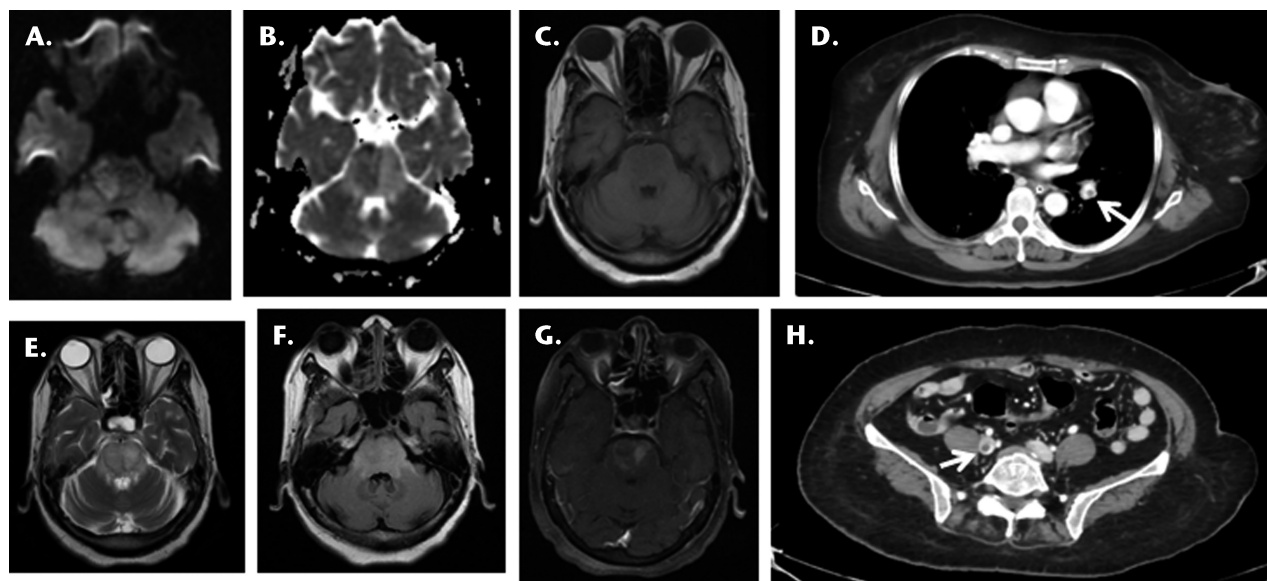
Magnetic resonance imaging of the brain during admission revealed patchy diffusion restriction (A) with corresponding hypointensity on ADC (B). There was T1 hypointensity (C) and T2/FLAIR hyperintensity (E and F) in the whole midbrain and pons including both the middle cerebellar peduncles (E, F) with swelling. On gadolinium administration, there was patchy heterogenous enhancement of the lesion (G). Contrast-enhanced CT of the chest revealed nonobstructing thrombus in the left pulmonary artery (D) and right common iliac vein (H).
